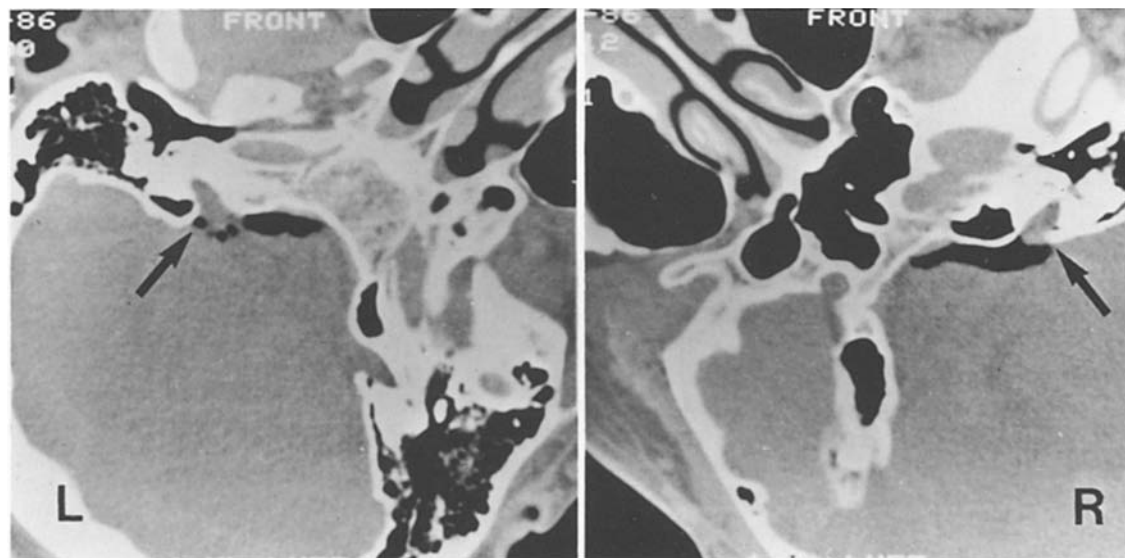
Bilateral, for the most part intra-canalicular acoustic neuroma as demonstrated by air-CT-cisternography (arrows)
